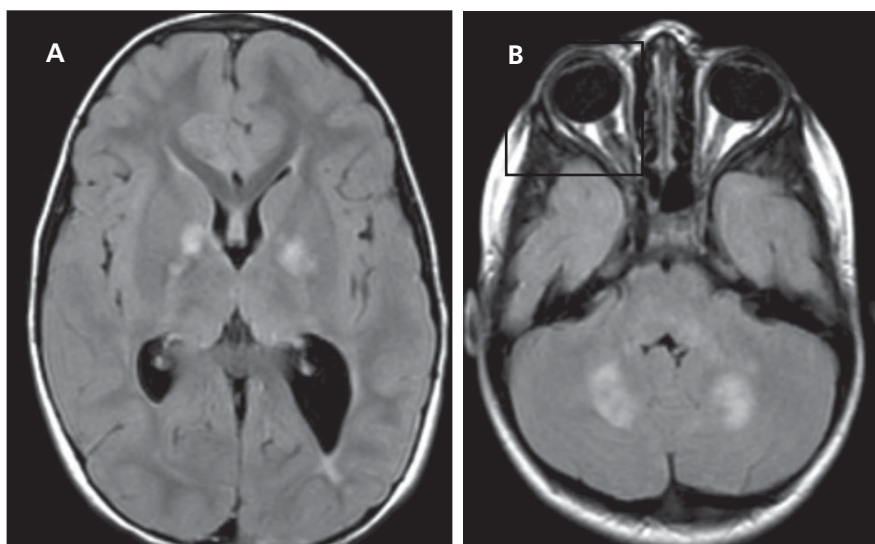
NF1 "spots." Axial fluid-attenuated inversion recovery (FLAIR) images demonstrate multiple foci of increased signal intensity without mass effect involving the basal ganglia and deep white matter tracts (A), as well as the cerebellum (including dentate nuclei) and the brainstem (B).
